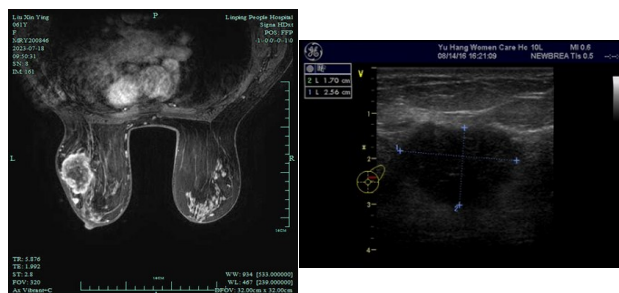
The representative MRI (left panel) and ultrasound images (right panel) of breast cancer patients. MRI images showed 45*4635 mm circular mass in the left breast, with BIRADS: 5. US imaging showed 2.6*1.7cm hypoecho mass in the left breast, with BI-RADS: 5
